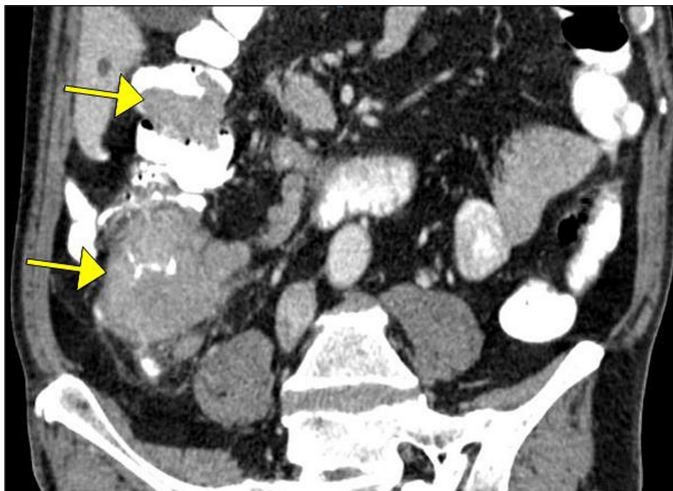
Axial and oblique coronal reformatted CT images of the abdomen and pelvis with oral and intravenous contrast demonstrate a $4.0 \times 3.1 \times .7\text{-cm}$ mass at the hepatic flexure of the colon, as well as an annular $6.3 \times 6.2 \times 6.3\text{-cm}$ mass slightly more proximally involving the cecum.
